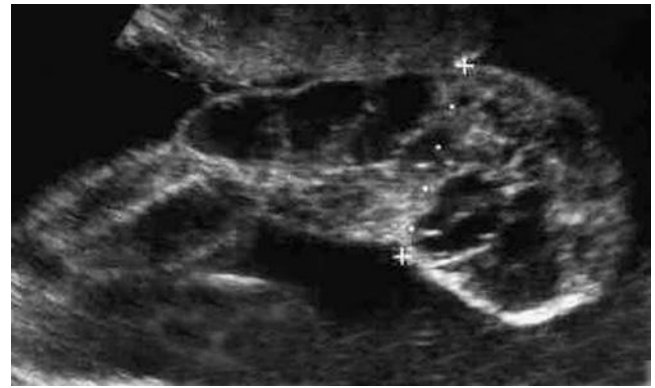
Klippel-Trenaunay syndrome. Sonogram of the leg of a fetus at 20 weeks' gestation with marked edema. (Courtesy of Carlos Alberto Mejia Escobar, 2000. Available at thefetus.net.)
